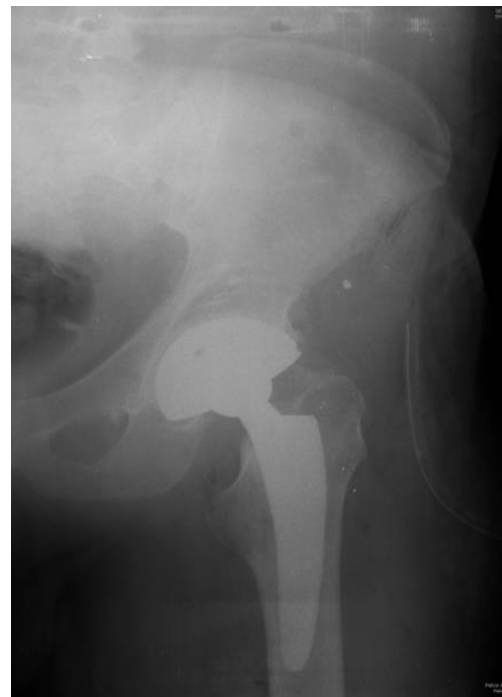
Radiography of the pelvis immediately after left hip arthroplasty with total cementless endoprosthesis with Zimmer Fitmore® Hip Stem
